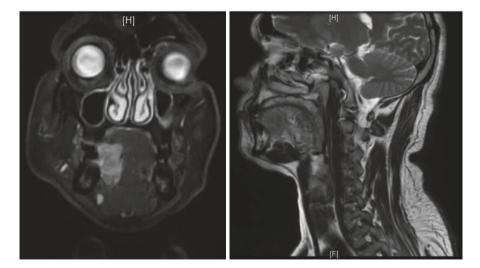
MRI of carcinoma of tongue
